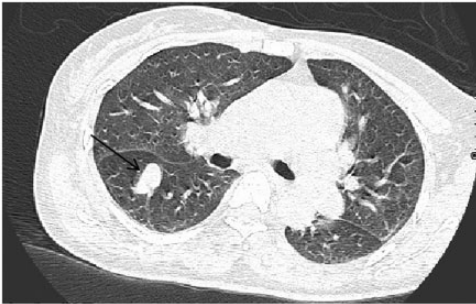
Computed tomography of the chest of a 43-year-old female patient, gravida 2, para 1, at 36 weeks of gestation, admitted in a stable condition following the diagnosis of placenta accreta for 1 month, demonstrated right lower lobe arteriovenous malformation (black arrow).
